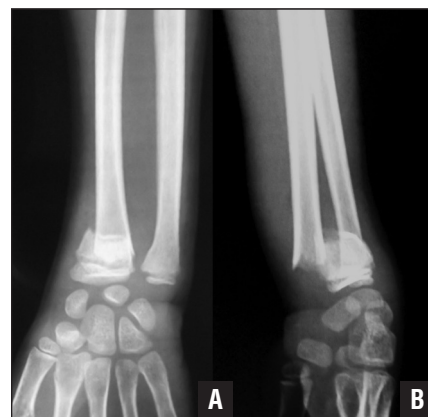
Preoperative anteroposterior (A) and lateral (B) radiographs of a completely displaced distal radius fracture in 10-year-old child.
